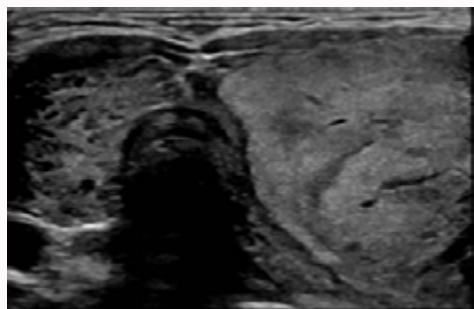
Ultrasound of the thyroid gland showed diffuse heterogeneous echotexture with an enlarged solid left lobe nodule measuring 4.16 cm × 3.04 cm × 4.4 cm that is hyperechoic with a smooth margin and no detected calcifications.
